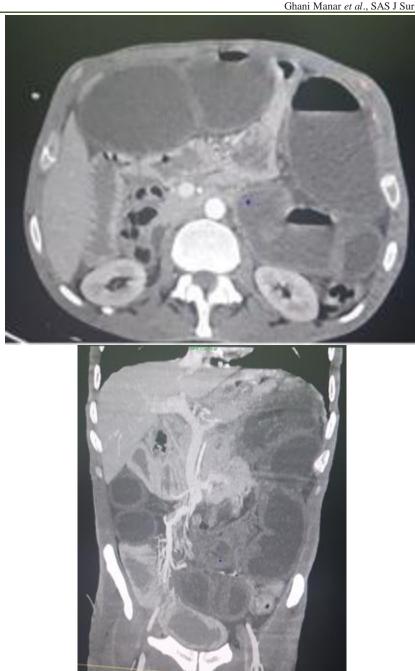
CT scan revealing incomplete small bowel volvulus on common mesentery
